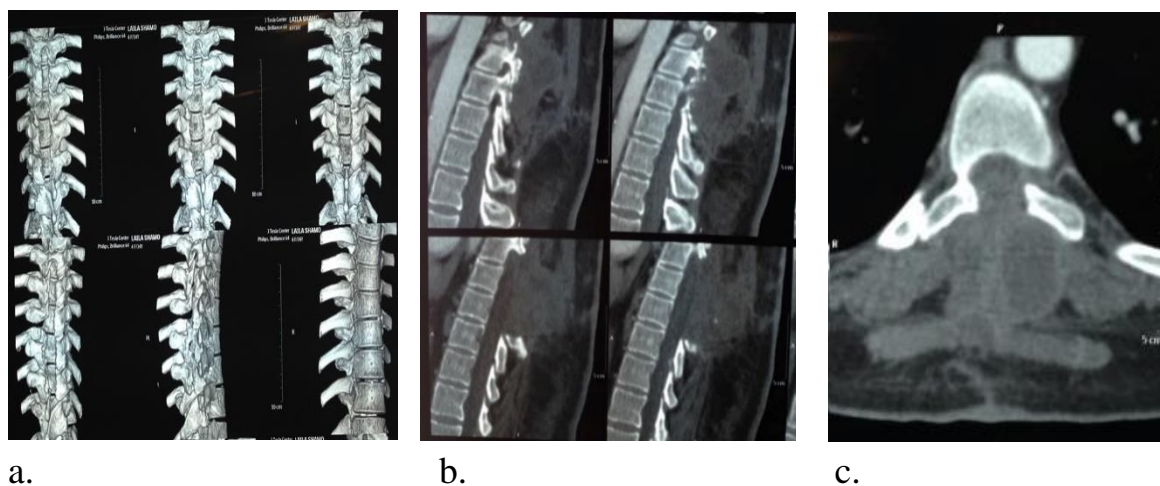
Post-operative CT pictures of part of the dorsal spine (a-c). All confirm local spinal stability.
